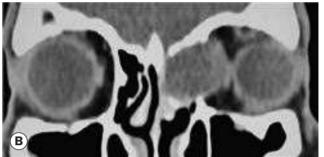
(A) Left ethmoidal sinus mucocoele causing dystopia; (B) coronal CT showing orbital involvement and indentation of the medial rectus
